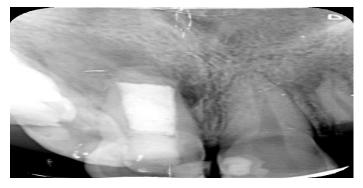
12 months follow-up radiographyDiscussionA. Pathogenesis of apical periodontitis in permanent immature teeth
